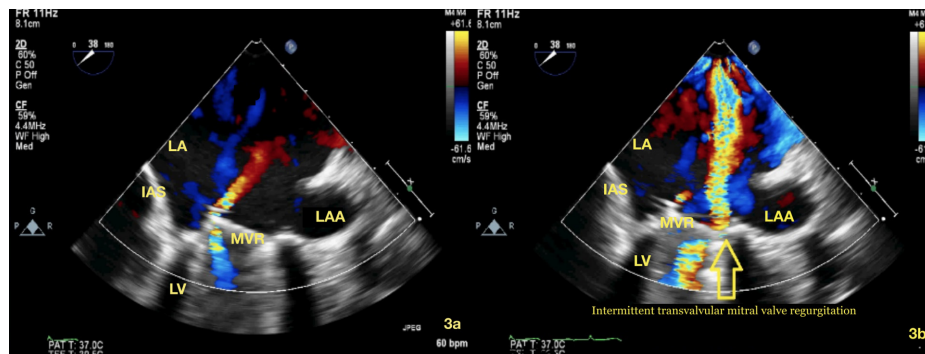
Transesophageal echocardiography image shows intermittent transvalvular mitral valve regurgitation due to entrapment by residual chordae. LA, left atrium; LV, left ventricle; LAA, left atrial appendage; IAS, interatrial septum; MVR, mitral valve replacement.
